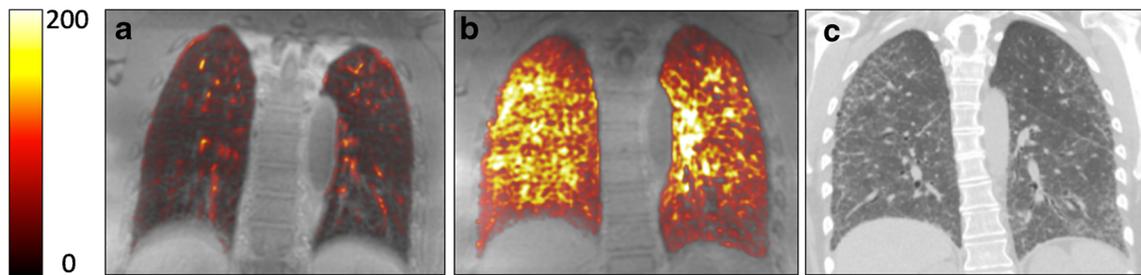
Molecular imaging of albumin extravasation in systemic sclerosis-associated interstitial lung disease. Fused MRI color overlay images (baseline pre-contrast images subtracted from images obtained 10–12.5 min post-contrast injection super-imposed on baseline image) for a healthy volunteer and b SSc-ILD patient. c CT scan of the SSc-ILD patient. For the healthy volunteer (a), the majority of the lungs are unenhanced with higher areas of signal intensity correspond to the location of blood vessels. Findings are similar to an angiogram as gadofosveset is bound to albumin in the blood. For the SSc-ILD patient
